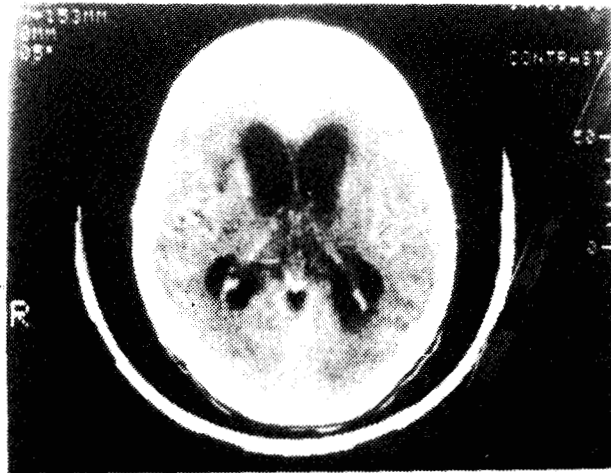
Post contrast CT scan of the head showing moderate hydrocephalic changes. A right frontal area of hypodensity is noted likely representing caudate nucleus infarction.
